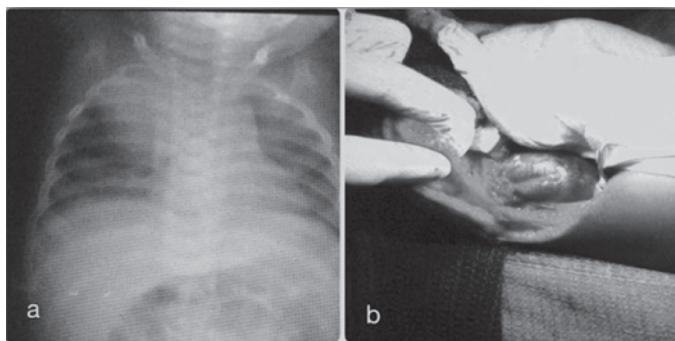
X-ray chest - Homogenous opacity in right upper lobe
